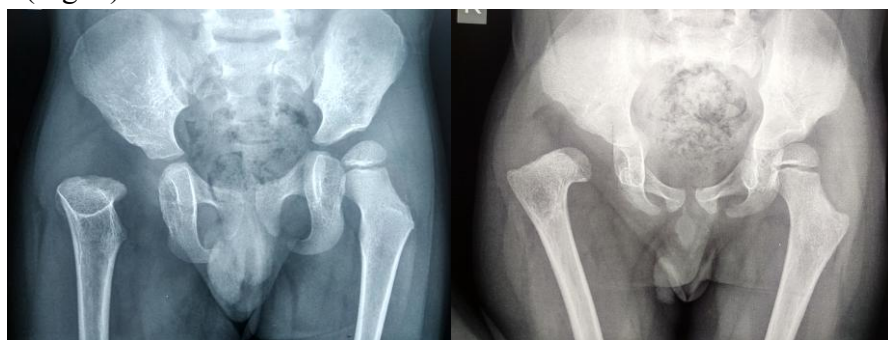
Anteroposterior radiograph of the hip joints. Position 0-rotation and internal rotation of the lower extremities: pathological destructive dislocation of the hips with destruction of the head and neck of the right femur.
